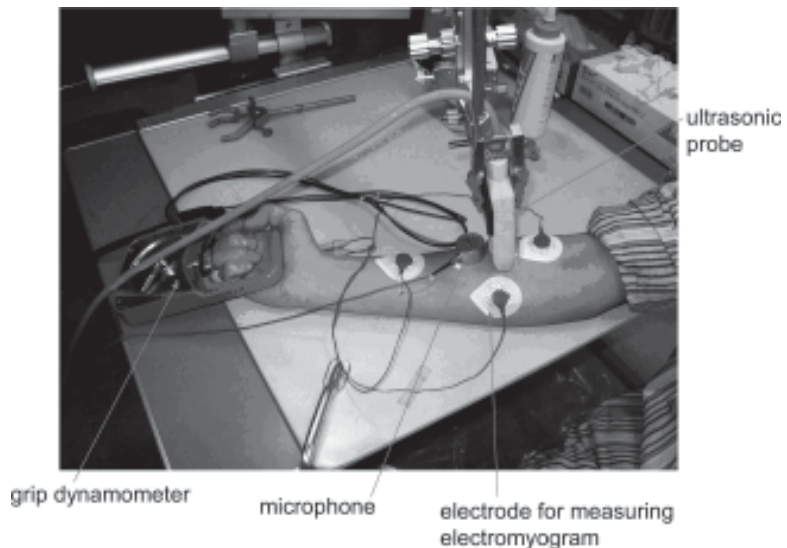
Apparatus for simultaneous measurement of surface electromyogram (EMG), phonomyogram (PMG) and Doppler myogram (DMG) in the forearm during grasp. Grip strength is measured using a grip dynamometer.
